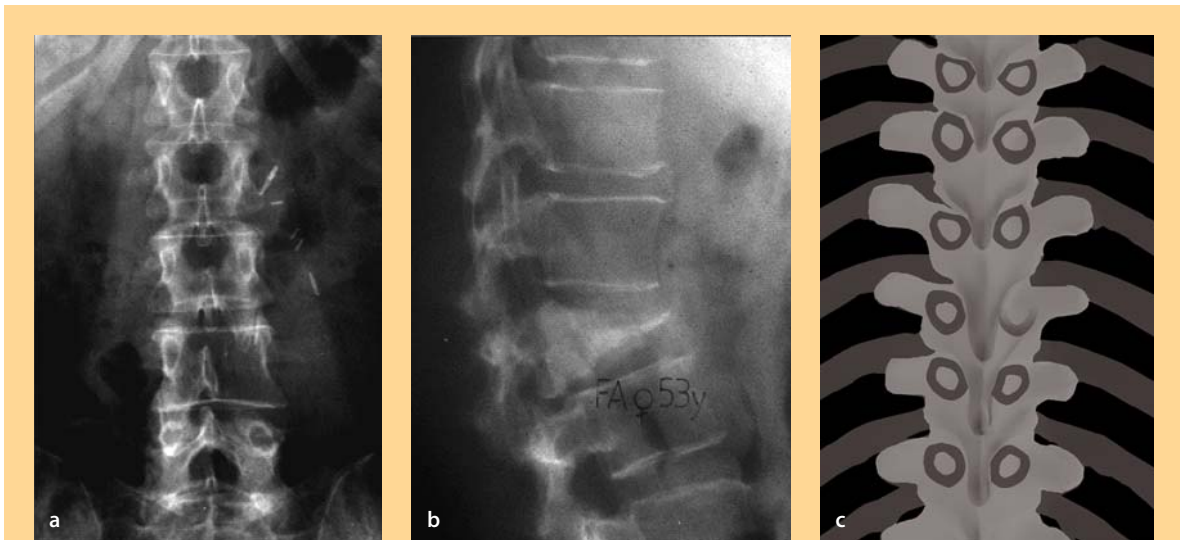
Radiographic findings in spinal metastases
